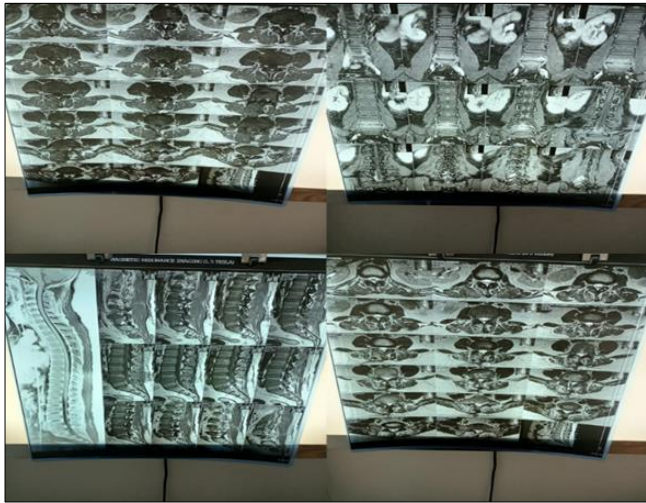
MRI of cervical spine revealing PLID
